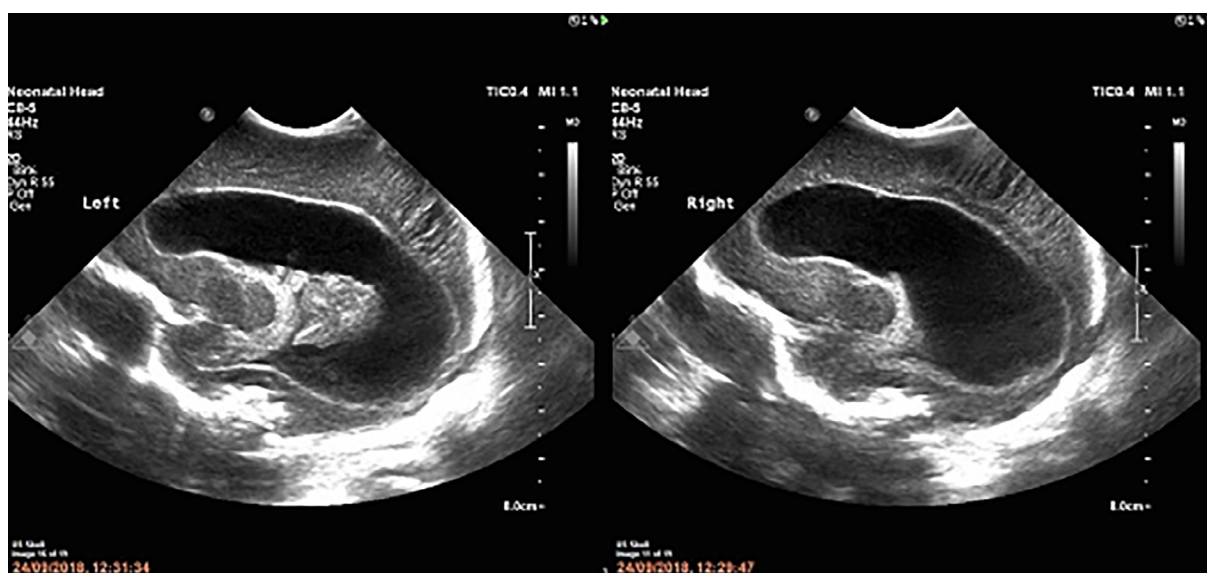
Left and right neonatal cranial ultrasound images at birth (case 1)
